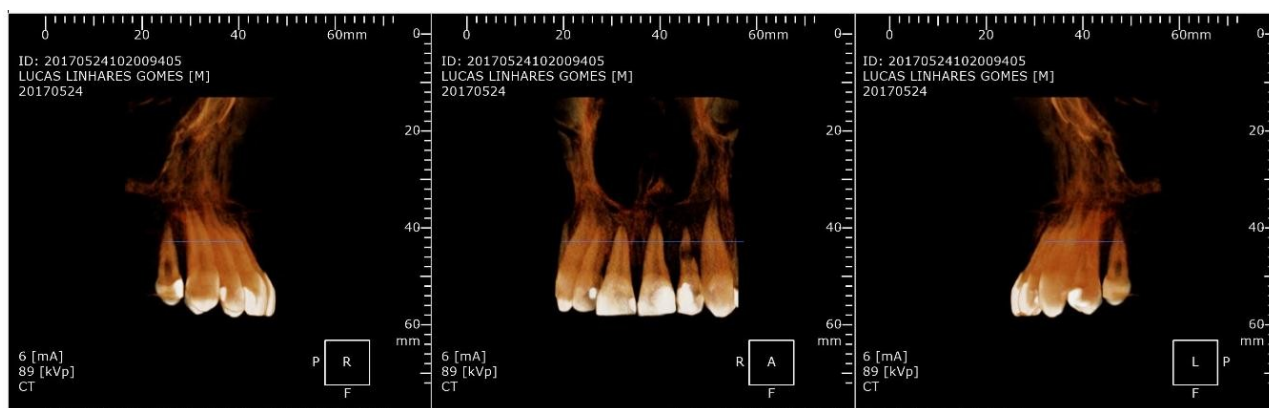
3D panoramic image of the Conical Beam Computed Tomography for diagnosis of the requested region.
